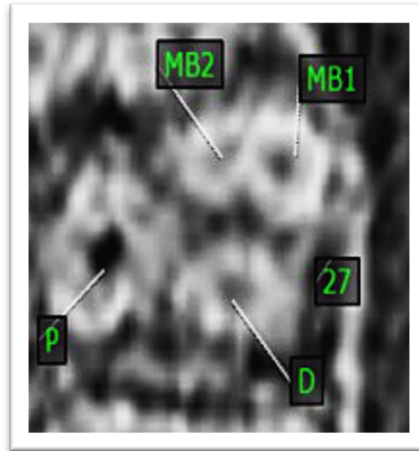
Cross-sectional CBCT image of left maxillary second molar with a clearly distinguished MB2 canal.
